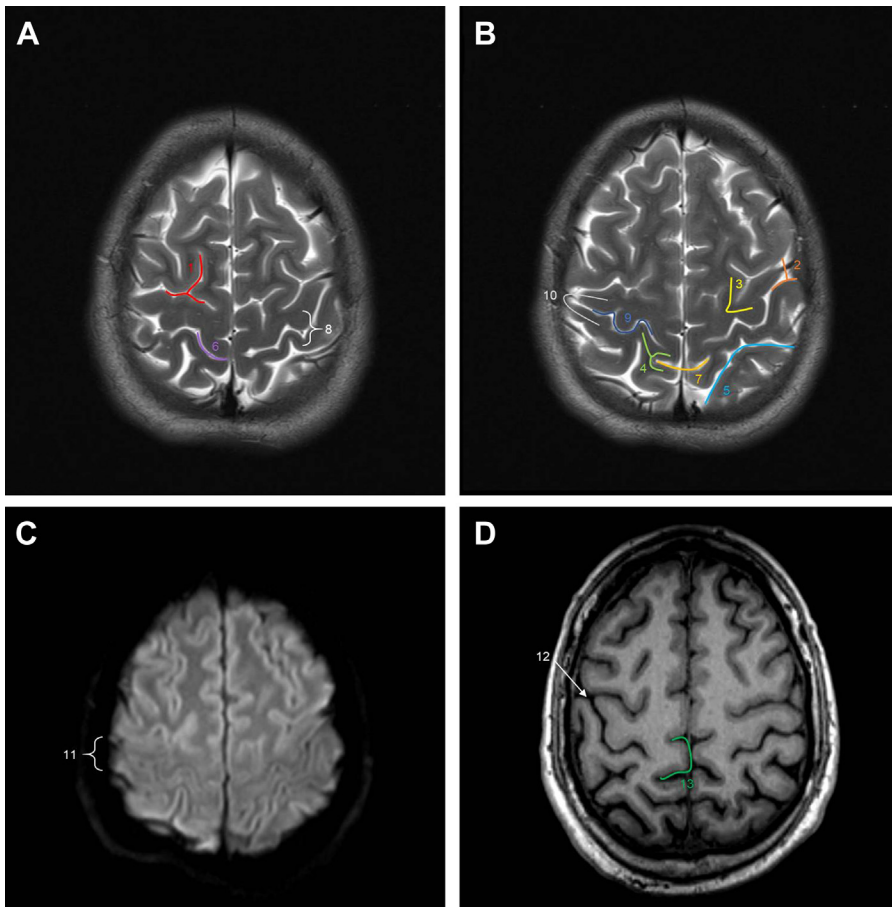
Montage of signs indicating the location of the central sulcus on (A, B) axial T2-weighted images, (C) axial diffusion-weighted image, and (D) axial T1-weighted MPRAGE image along the superior convexity. 1, Superior frontal sulcus-precentral sulcus sign (upper T sign); 2, inferior frontal sulcus-precentral sulcus sign (lower T sign); 3, L sign; 4, bifid postcentral gyrus sign; 5, intraparietal sulcus sign; 6, midline sulcus sign; 7, pars bracket sign; 8, thin postcentral gyrus sign; 9, handknob or reverse-omega sign; 10, U sign; 11, invisible cortex sign; 12, white gray sign; 13, white paracentral lobule sign.
